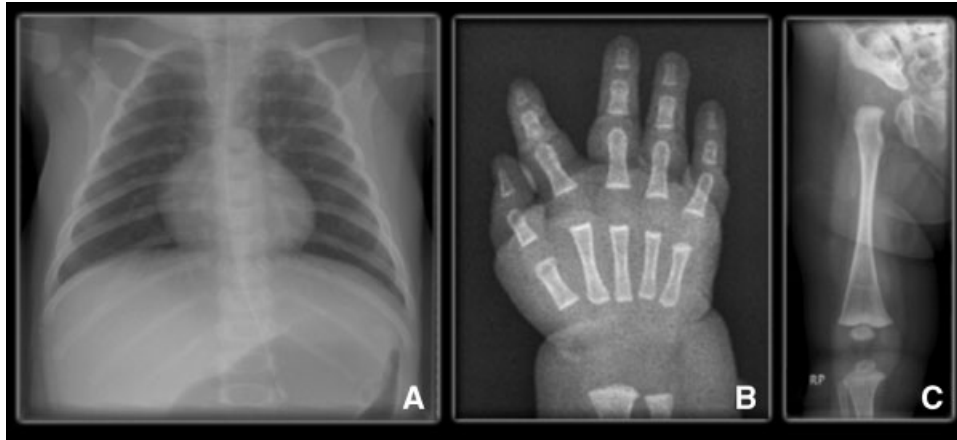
Radiographic images of Patient 2 (A) chest X-ray: note widened rib metaphyses, and only 11 ribs on the right; (B) right hand X-ray: metaphyseal cupping of the short tubular bones, observed best in the metacarpals and proximal phalanges; (C) right lower limb and pelvis X-ray: note absence of capital femoral epiphyses.
